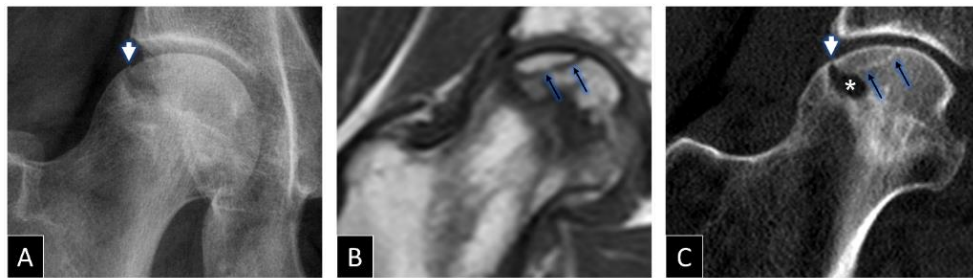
ARCO-3A FHON in a 35 yo man. (A) Anteroposterior radiograph shows ON associated structural bone changes of the femoral head with mild collapse of the subchondral bone plate (arrowhead). (B) Coronal T1-weighted MRI image shows a low T1 line (arrows) within the necrotic territory. (C) Corresponding coronal MDCT reformat shows collapse-related cortical interruption (arrowhead), trabecular impaction (arrows), and bone resorption (asterisk).
